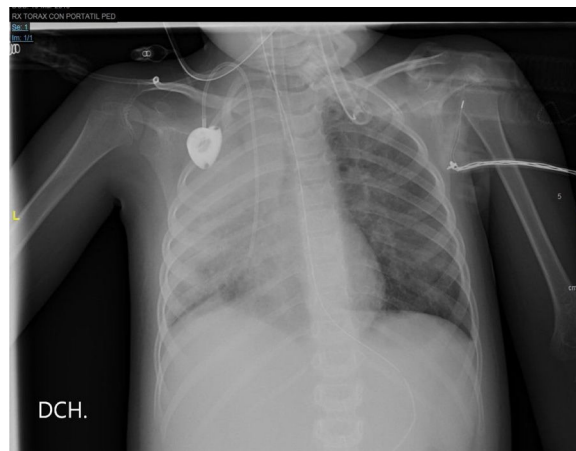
Thoracic x-ray.
